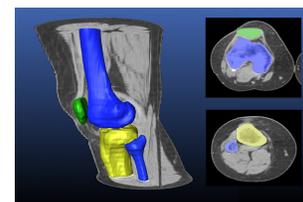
CT scan of the normal knee
